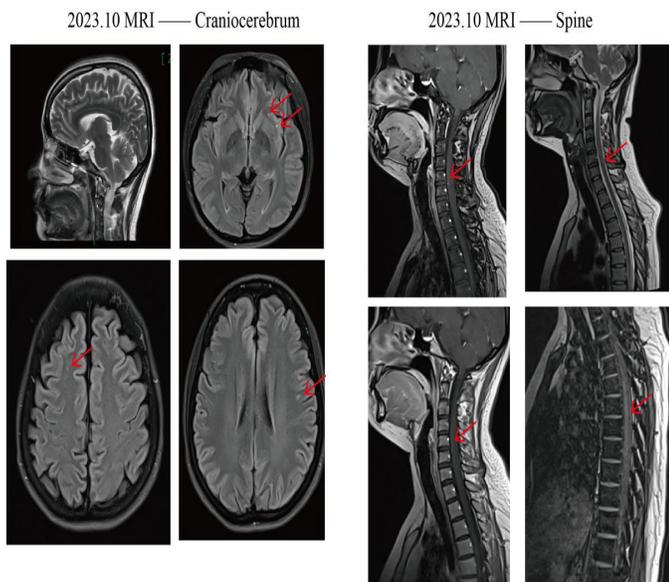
Axial and sagittal MRI images of the brain and whole spine obtained on October 6, 2023. Red arrows indicate areas of demyelinating signal abnormalities and high T2 signal within the spinal cord.
